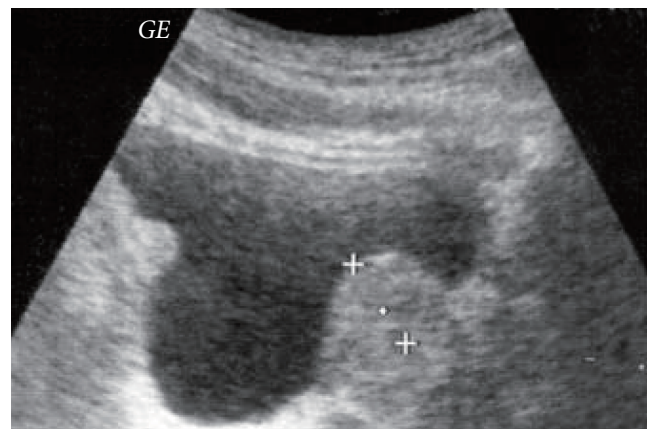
Abdominal ultrasound demonstrating the intravesical protrusion of the prostate (between the two crosses).
